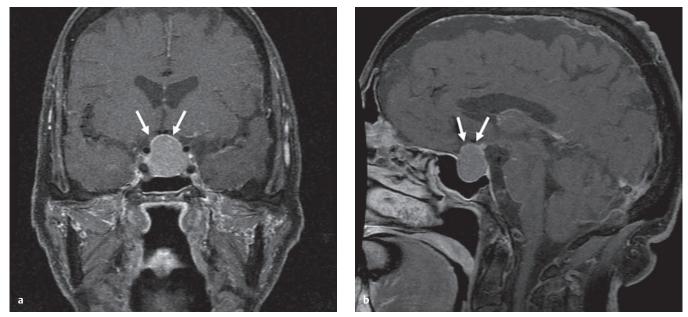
T1-weighted coronal (a) and sagittal (b) magnetic resonance imaging (MRI) after administration of contrast demonstrating a macroadenoma with suprasellar extension. Note the location of the residual pituitary gland (*arrows*) which appears as a rim of enhancing tissue superior and posterior to the tumor.
